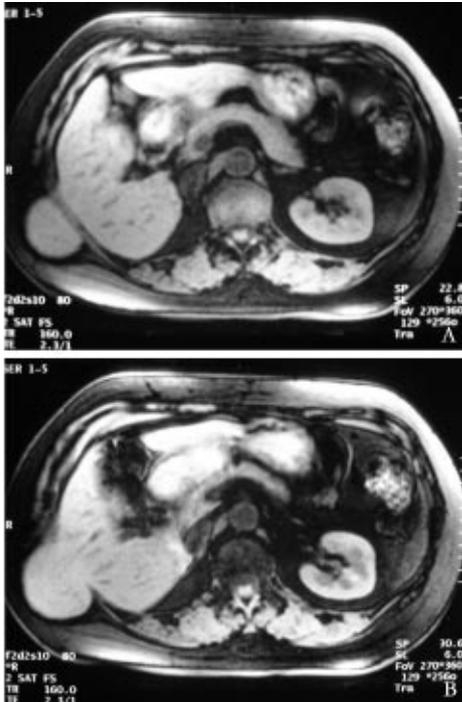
Magnetic resonance imaging scans demonstrating incarceration of the segmental right liver lobe through a lumbar defect.
